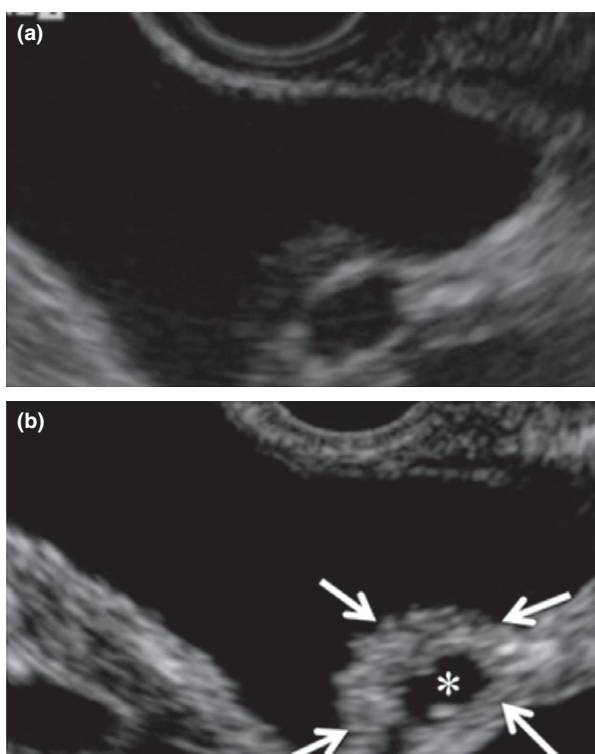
Typical case of adenomyomatosis. (a) Fundamental B-mode endoscopic ultrasonography (monitor mode). Localized wall thickening with an anechoic area is detected in the gallbladder. (b) Contrast-enhanced harmonic endoscopic ultrasonography. The lesion (arrows) is homogeneous, with a clear perfusion enhancement defect (*).
